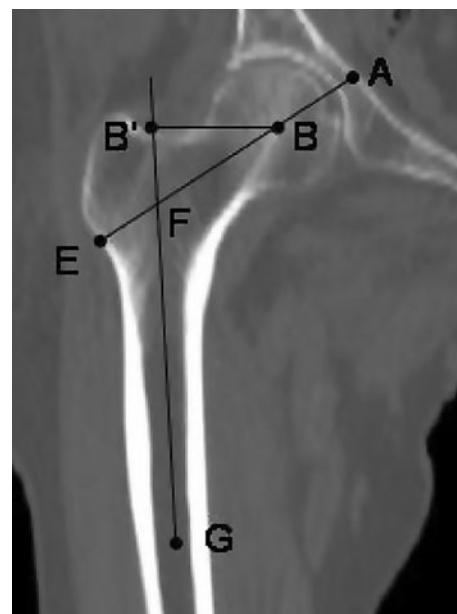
CT images were used to measure morphologic features of the hip: head axis length (HAL), defined as the length along the femoral neck axis from the lateral aspect of the greater trochanter to the inner pelvic rim (AE); femoral neck axis length (FNAL), defined as the length of the neck axis between the head center and the femoral medullary axis (BF); neck-shaft angle (NSA); neck width; and head offset (BB').
